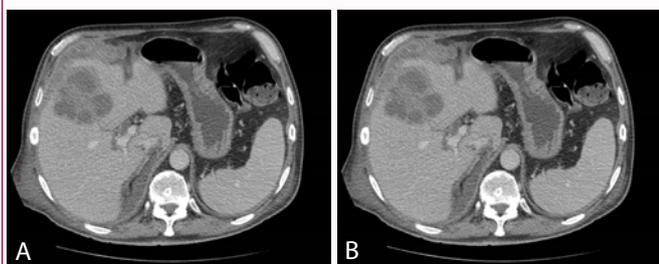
Abdominal CT-scan showing the evolution of the hepatic abscess. Figure A - Admission day; Figure B - After drainage of the abscess (7 days later).
